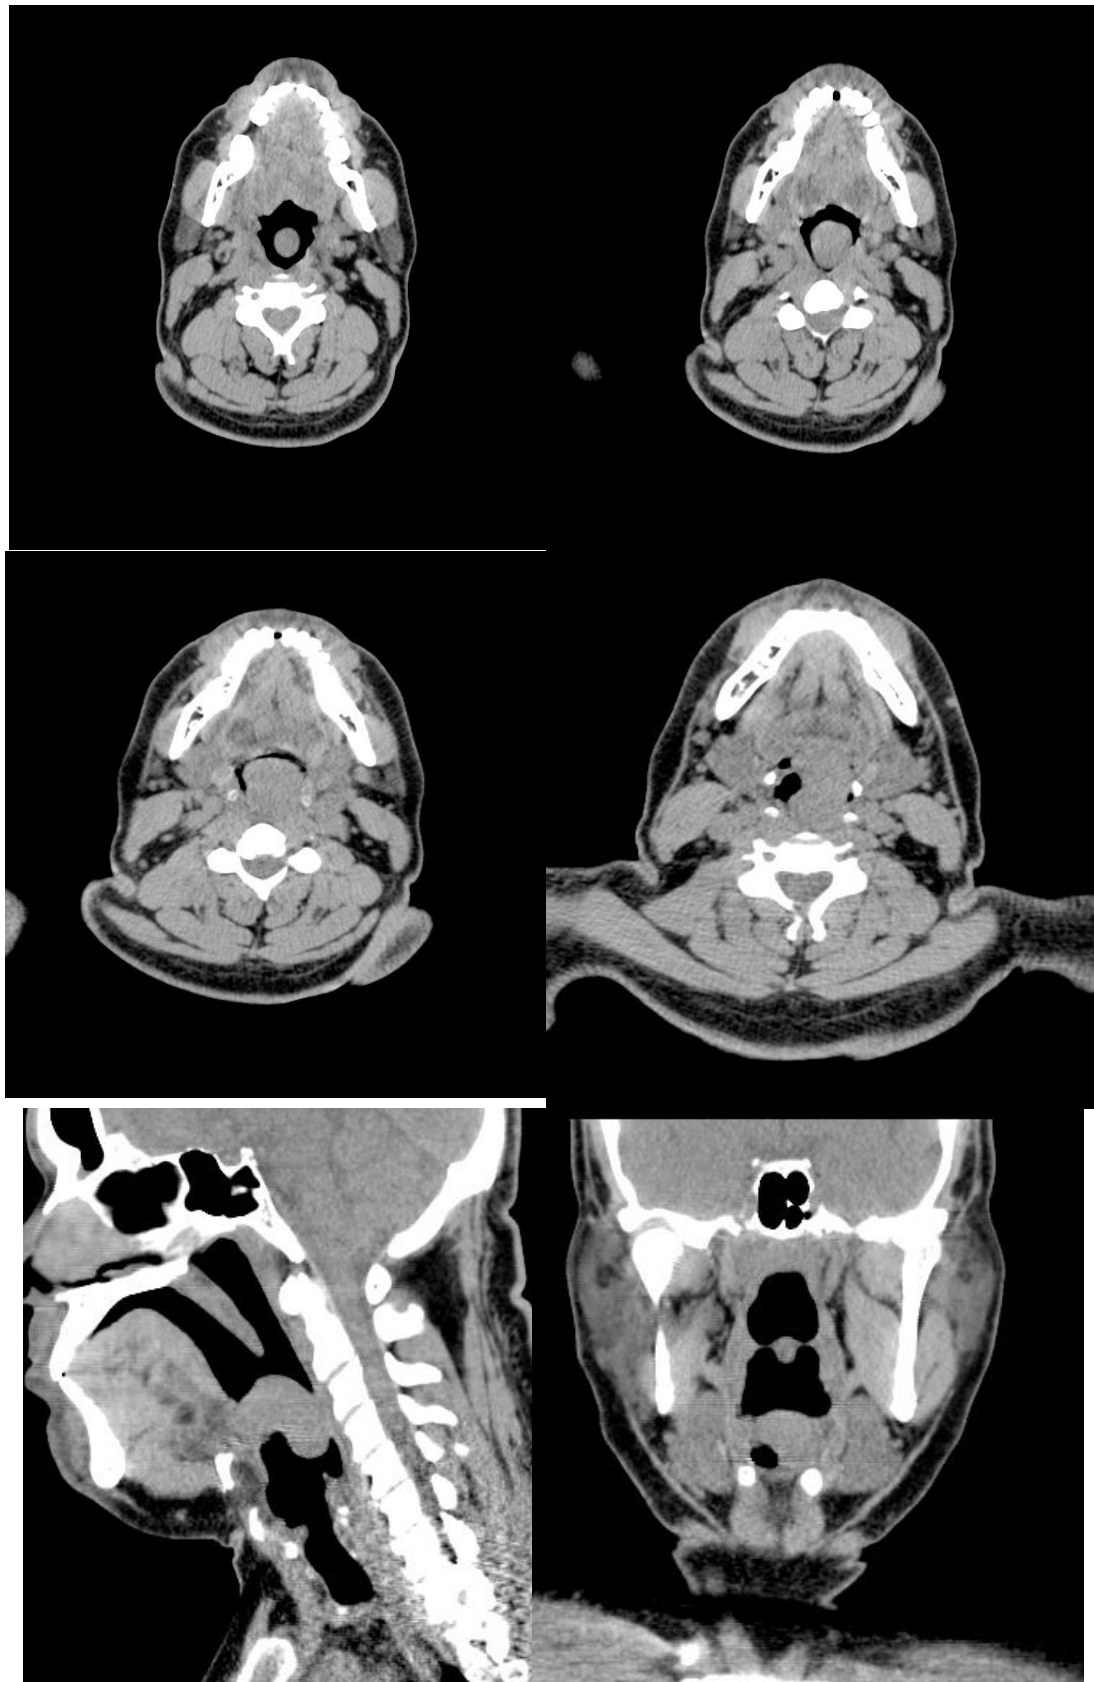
NCCT (Non contrast computed tomography) NECK showing a well- defined ovoid soft tissue density lesion occupying the lower oropharynx and superior aspect of laryngopharynx causing near complete occlusion of the airway. Anteriorly the lesion was seen occupying the left vallecula and extending across the midline towards the right.
